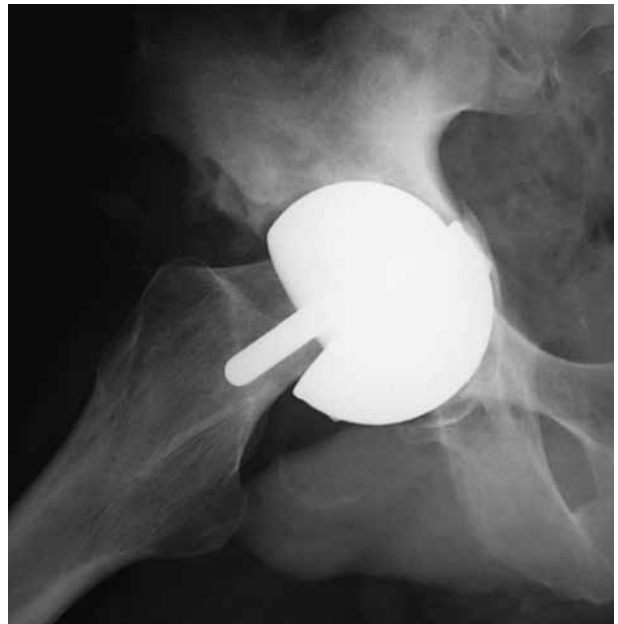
Radiograph at failure with marked cup displacement
